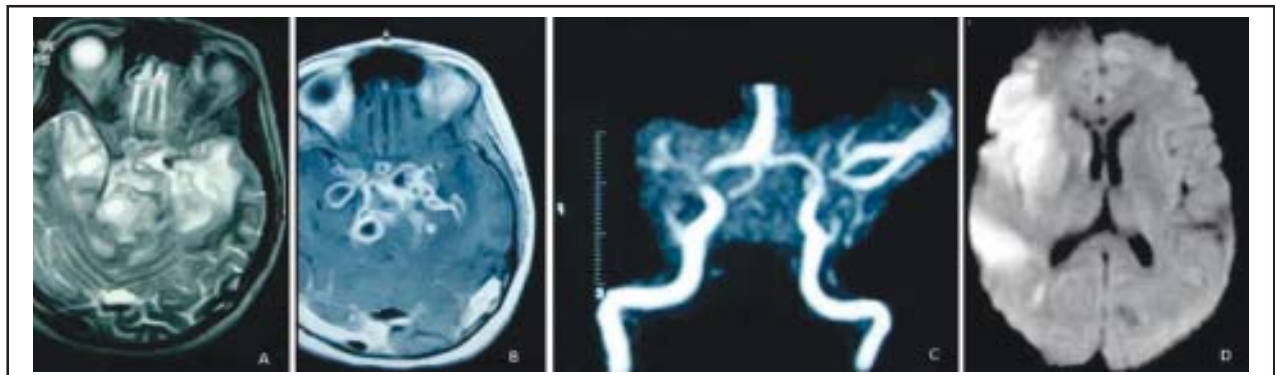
MRI Brain of an 18 year old girl who presented with fever, drowsiness and multiple cranial nerve palsies and developed weakness of left side of body approximately 2 weeks after the initial symptoms.
